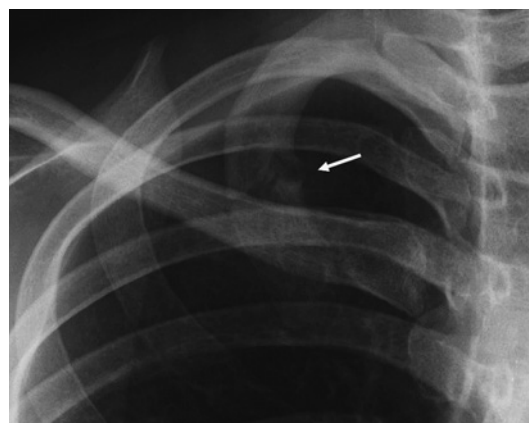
A plain radiograph of the right first rib showing a fracture line (arrow).
